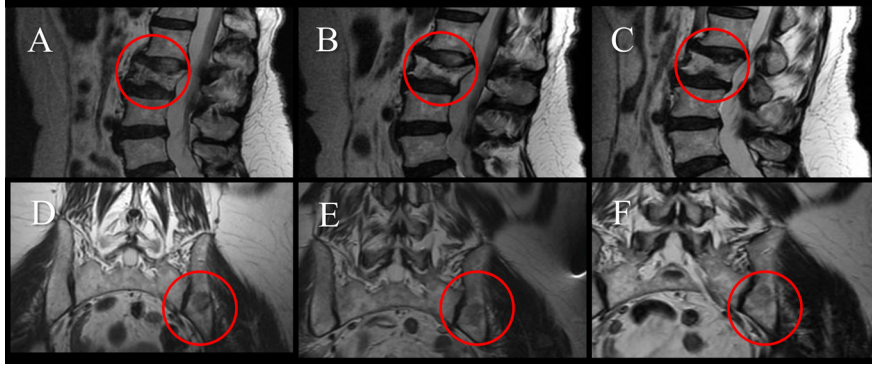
Magnetic Resonance Imaging (MRI) of female patient with metastatic non-Hodgkin's lymphoma (Case 4). Images in sagittal view showed pathological fracture in the L3 vertebra, 2020 (A), and the resolution from 2021 (B) and 2022 (C). Images showed decreased metastatic activity in both L3 and iliac bone from 2020 (D), 2021 (E) and 2022 (F).
